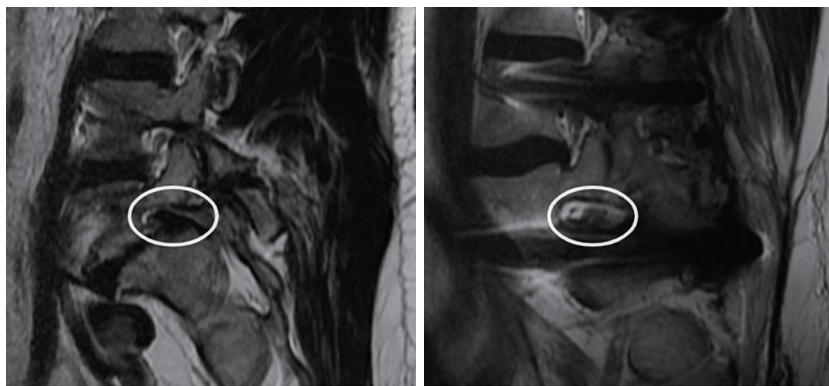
Preoperative and postoperative MRI demonstrating decompression of the L5-S1 foramina (circle). MRI, magnetic resonance imaging.
